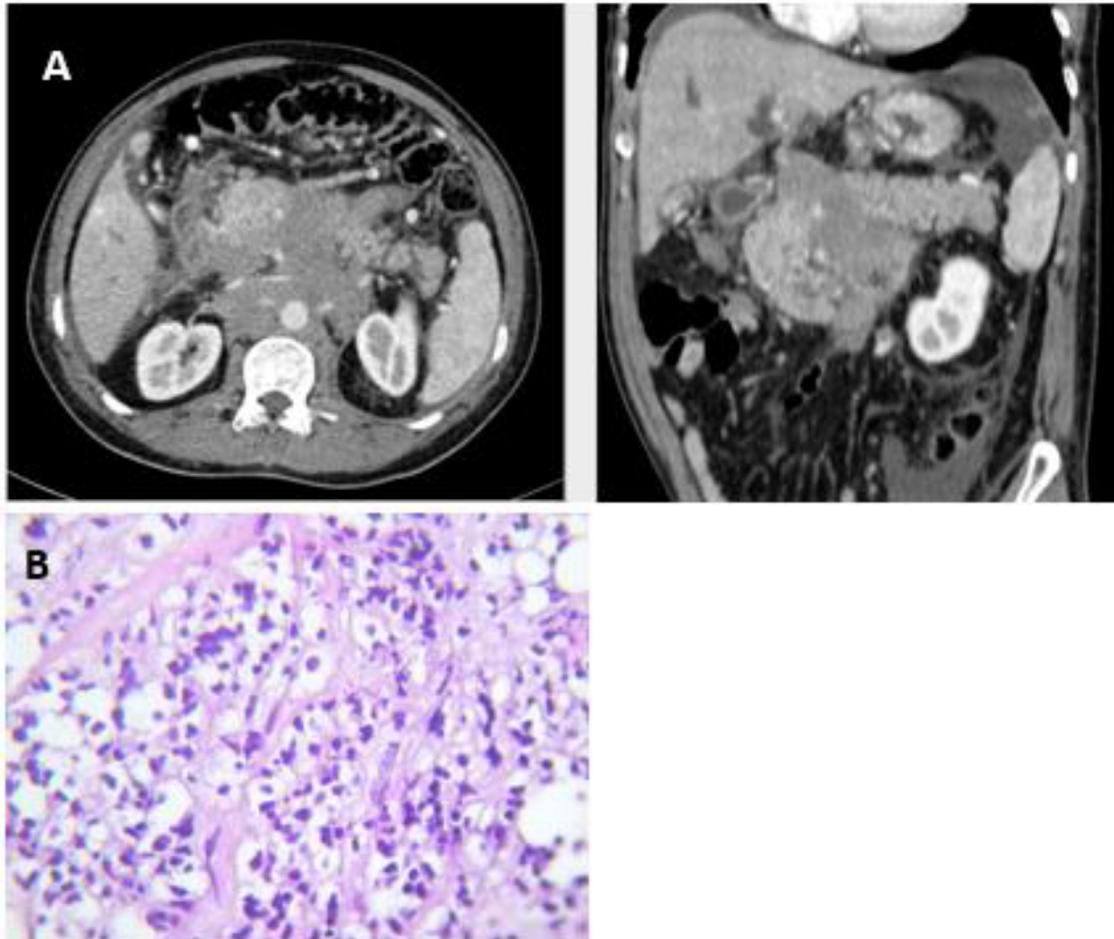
(A) Abdominal CT scan showed a lesion of the head and body of the pancreas, infiltrating the duodenum. (B) Cytological results of the fourth case confirming the diagnosis of diffuse large cell B lymphoma.
